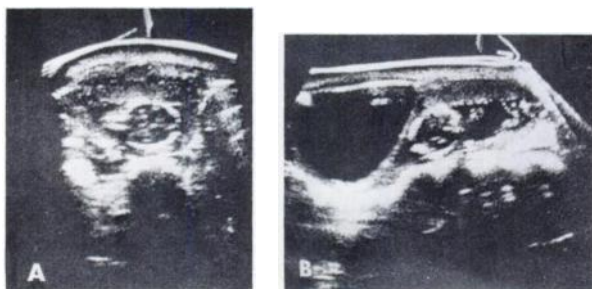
Representative ultrasonic scans demonstrating anterior implantation of placenta. (A) Transverse scan, 6 cm below umbilicus. (B) Longitudinal scan, 1 cm to the left of midline. Singleton fetus in vertex presentation and filled urinary bladder are also shown. Both scans were obtained with patient supine.
